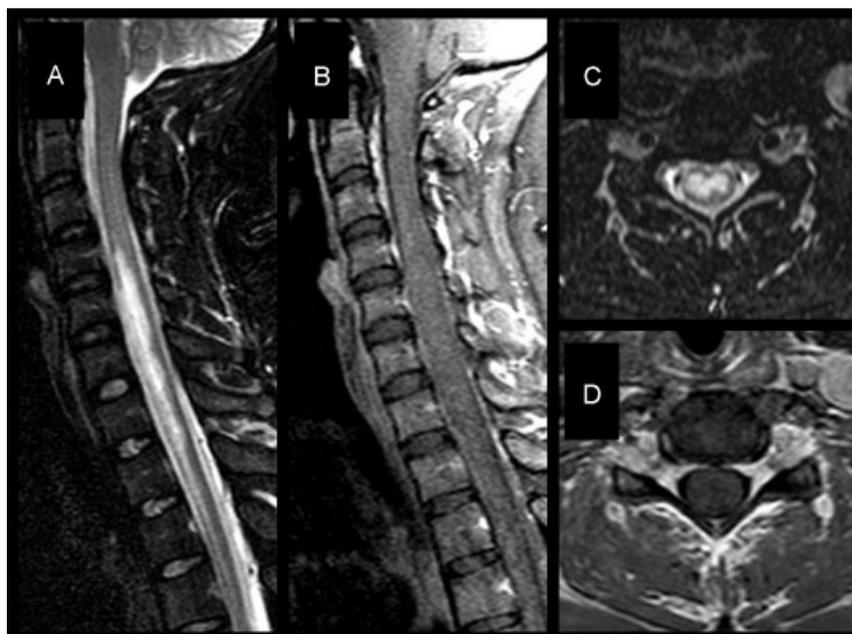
Anterior spinal artery infarct. This is a 33-year-old woman with acute onset of quadriparesis. Sagittal short T₁-inversion recovery (STIR) (A) and fat-suppressed gadolinium-enhanced T₁-weighted magnetic resonance images (MRIs) (B) show confluent signal abnormality spanning from C₄–T₁, without corresponding enhancement. Axial STIR (C) and axial gadolinium-enhanced T₁-weighted MRIs (D) show signal largely confined to gray matter, with preservation of the normal flow voids within the codominant vertebral arteries.
